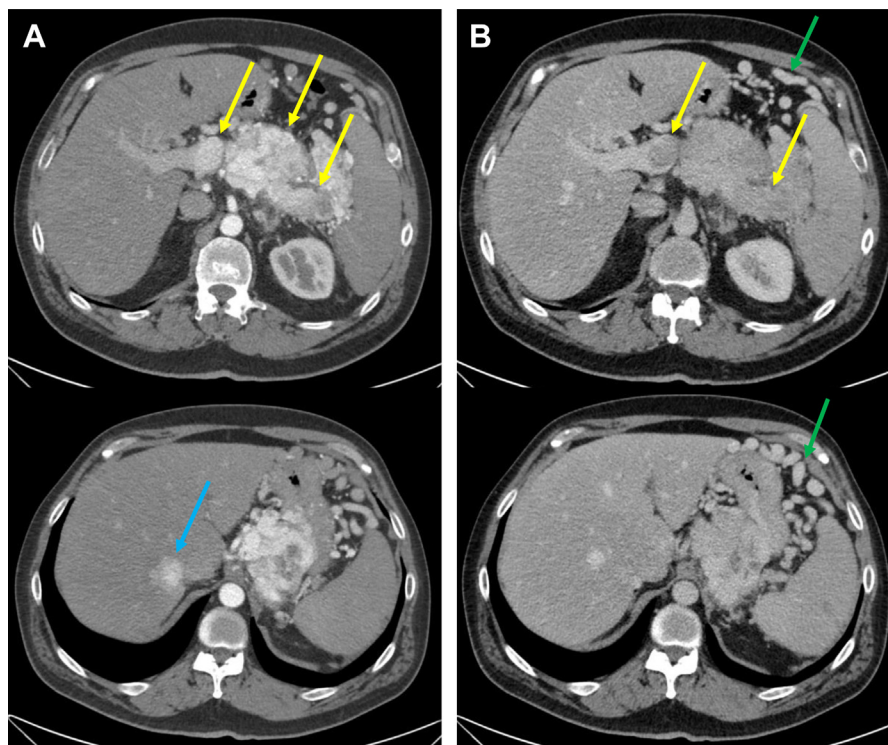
G3 NET of the pancreatic tail, patient presenting with gastrointestinal bleed. Multi-phase contrast-enhanced CT of the abdomen, arterial (A) and portal venous (B) phases. The mass enhances on the arterial phase, with a tumor thrombus involving the splenic and portal veins (yellow arrows), and collateral veins in the left abdomen (green arrows). Hyperenhancing liver metastasis is seen only on the arterial phase (blue arrow).
